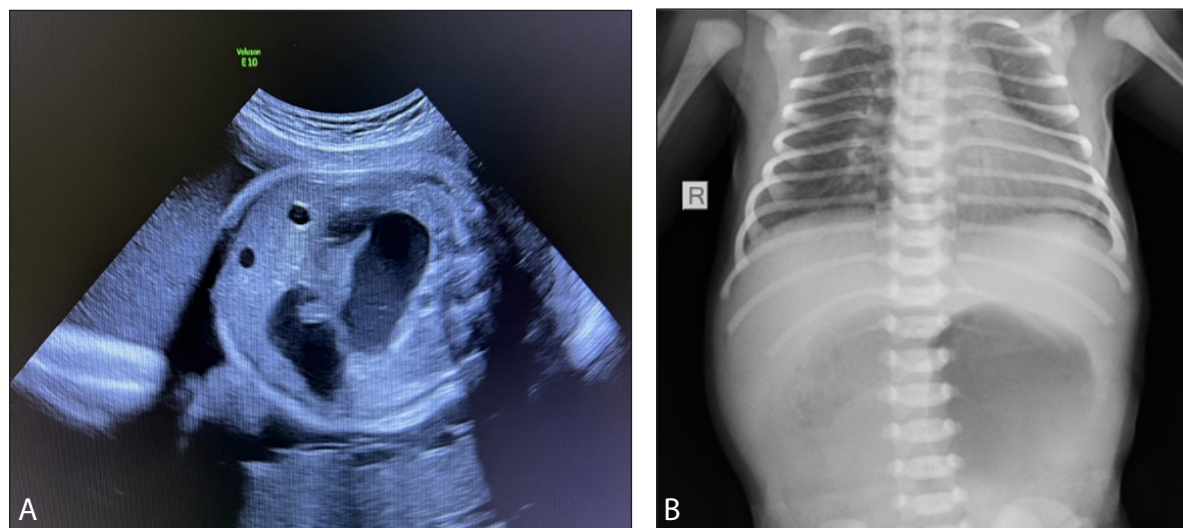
A. Antenatal ultrasonography 27/28 week GA revealed two hypoechoic formations (a dilated stomach and a dilated duodenum) and a distal small bowel; B. X-ray abdomen showed “double-bubble” sign, while the rest of the abdomen was gasless.
